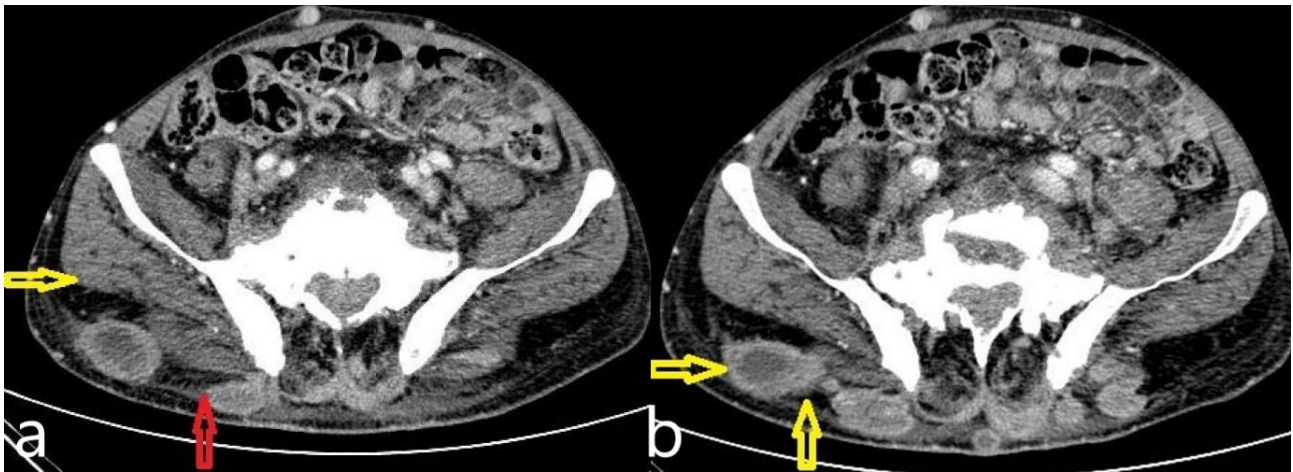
a) Axial CT scan showing subcutaneous edema (red arrow) below the inguinal region and intramuscular edema at the posterior part of the leg (yellow arrow). b) Axial CT scan revealing multiple communicating tracks in the right gluteal region
